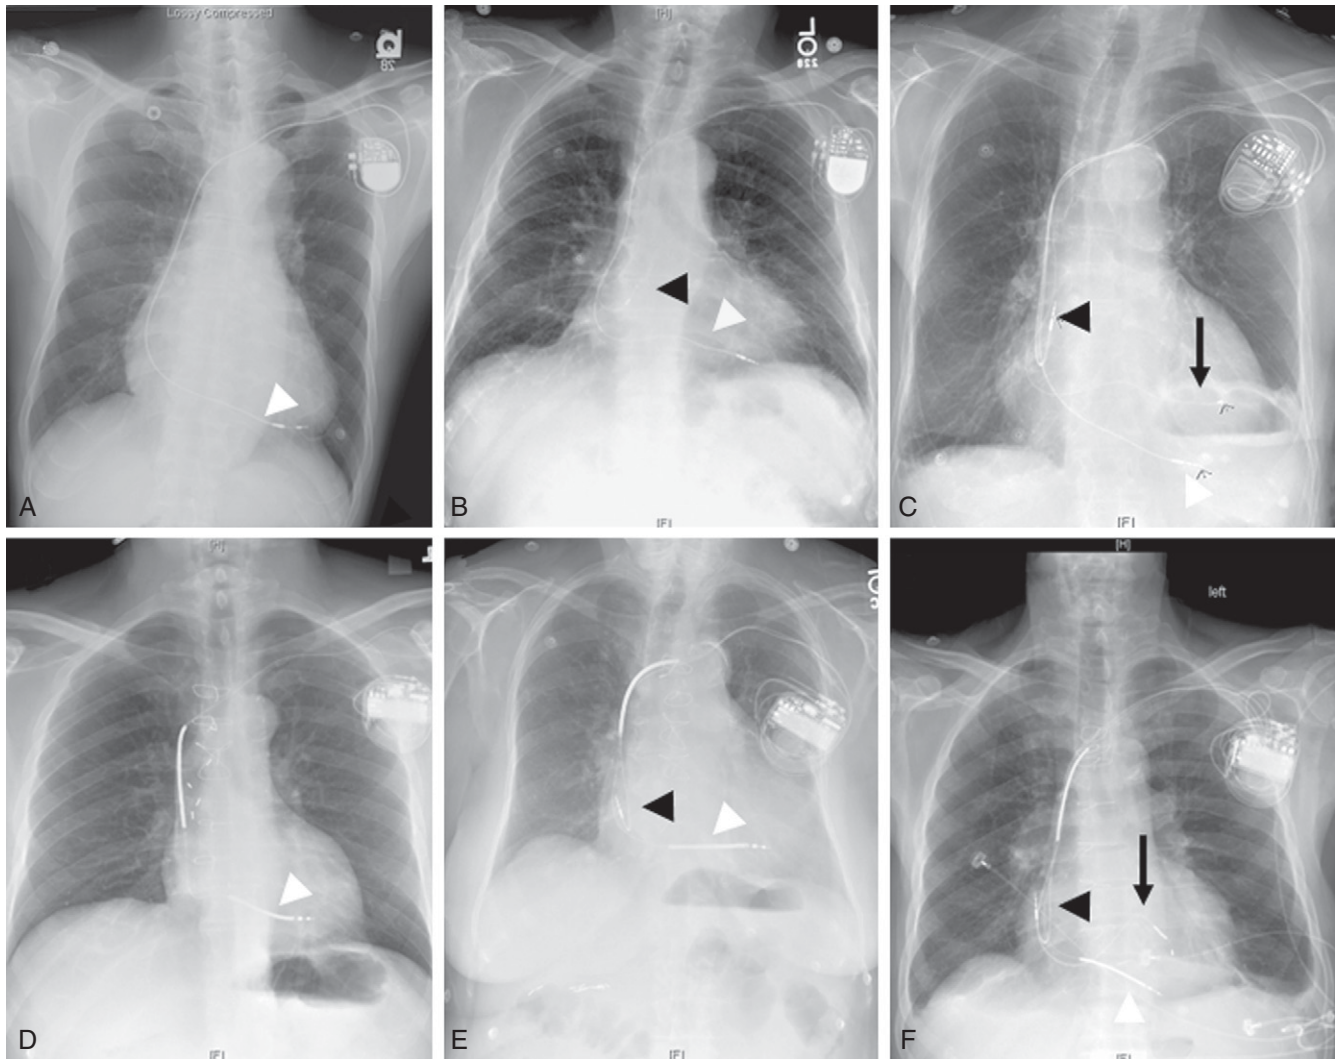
Chest roentgenogram appearance of standard pacemaker and implantable cardioverter-defibrillator (ICD) systems is shown. A, Single-chamber pacemaker; B, Dual-chamber pacemaker; C, Biventricular pacemaker; D, Single-chamber ICD; E, Dual-chamber ICD; F, Biventricular ICD. Single-chamber systems consist of a right ventricular (RV) electrode (white arrowhead). Dual chamber systems have a right atrial (black arrowhead) and RV electrode, while biventricular systems have a third lead positioned in the coronary sinus (black arrow).
